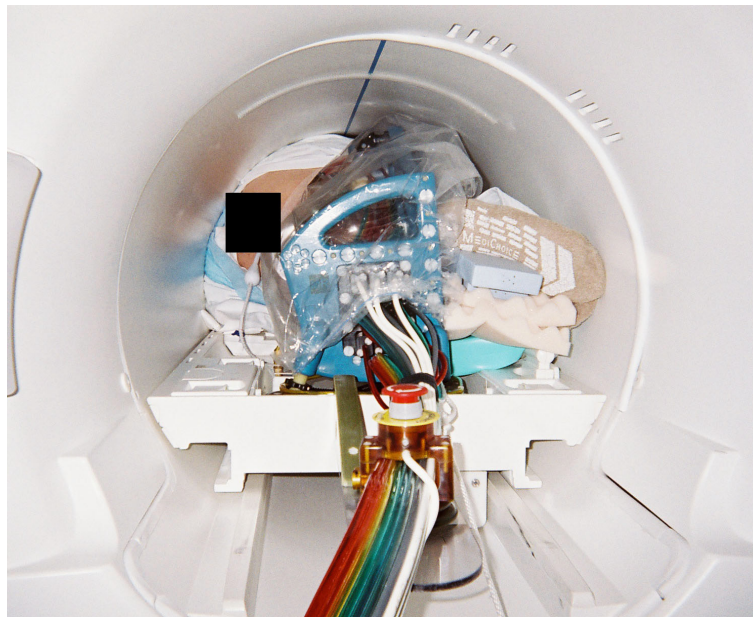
Patient and the MRI-Safe robot in the scanner for the first clinical trial
